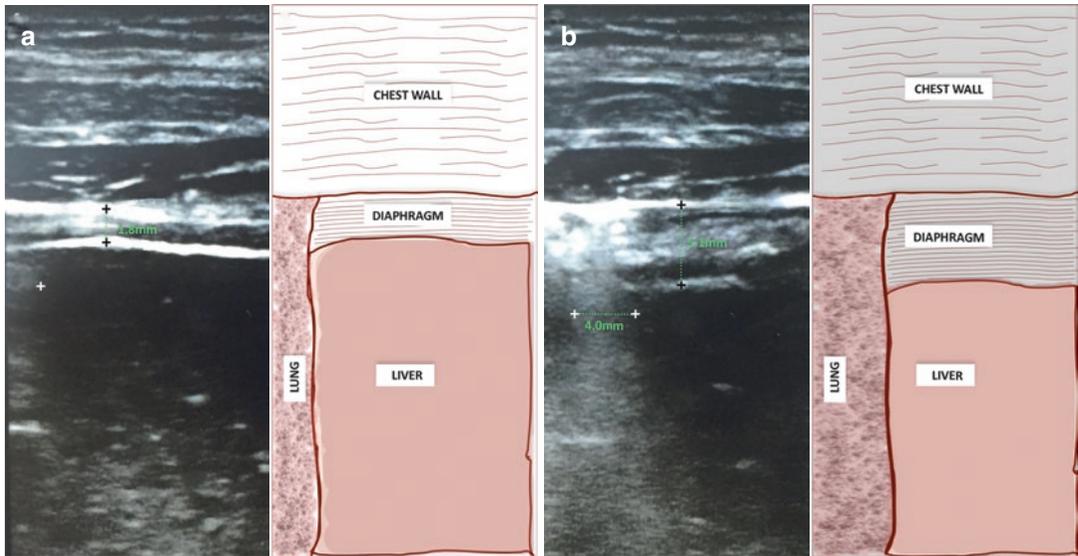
A high resolution 13–6 MHz ultrasound linear probe (SonoSite Edge, SonoSite, Inc., Washington USA) held perpendicular to the chest was used to evaluate real-time movement of the diaphragm in the zone of apposition. Measurements obtained were recorded in B mode (two dimensional) ultrasonography by placing the transducer along the line of an intercostal space between the right anteroaxillary and midaxillary lines to ensure the zone of apposition is visualized ~0.5–2 cm below the right costophrenic sinus. Air in the lungs facilitates easy
